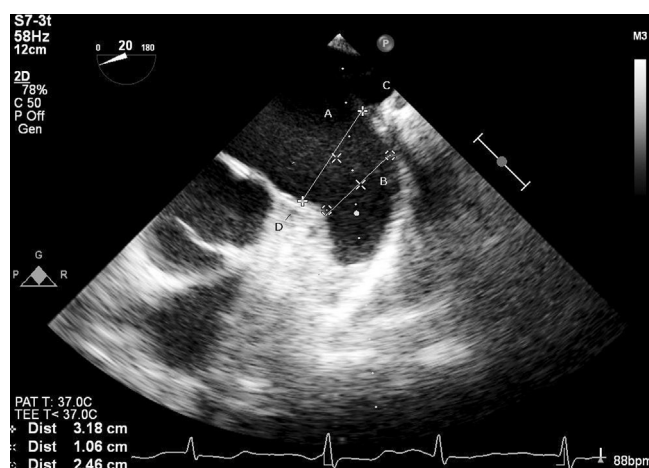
Transesophageal echocardiography showing the LAA and the measurements to be taken (A – ostium of LAA; B – measurement of the landing zone which is 10 mm inside the ostium perpendicular to neck of LAA; C – LUPV; D – LCX).
